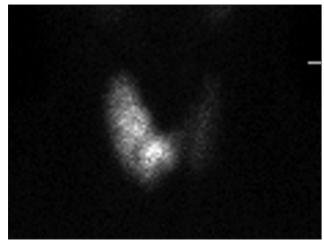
Technetium 99 thyroid scintigraphy: hyperfunctioning thyroid nodule involving entire right lobe
